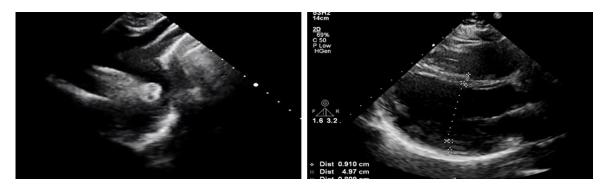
Echocardiography after PDA closure.
